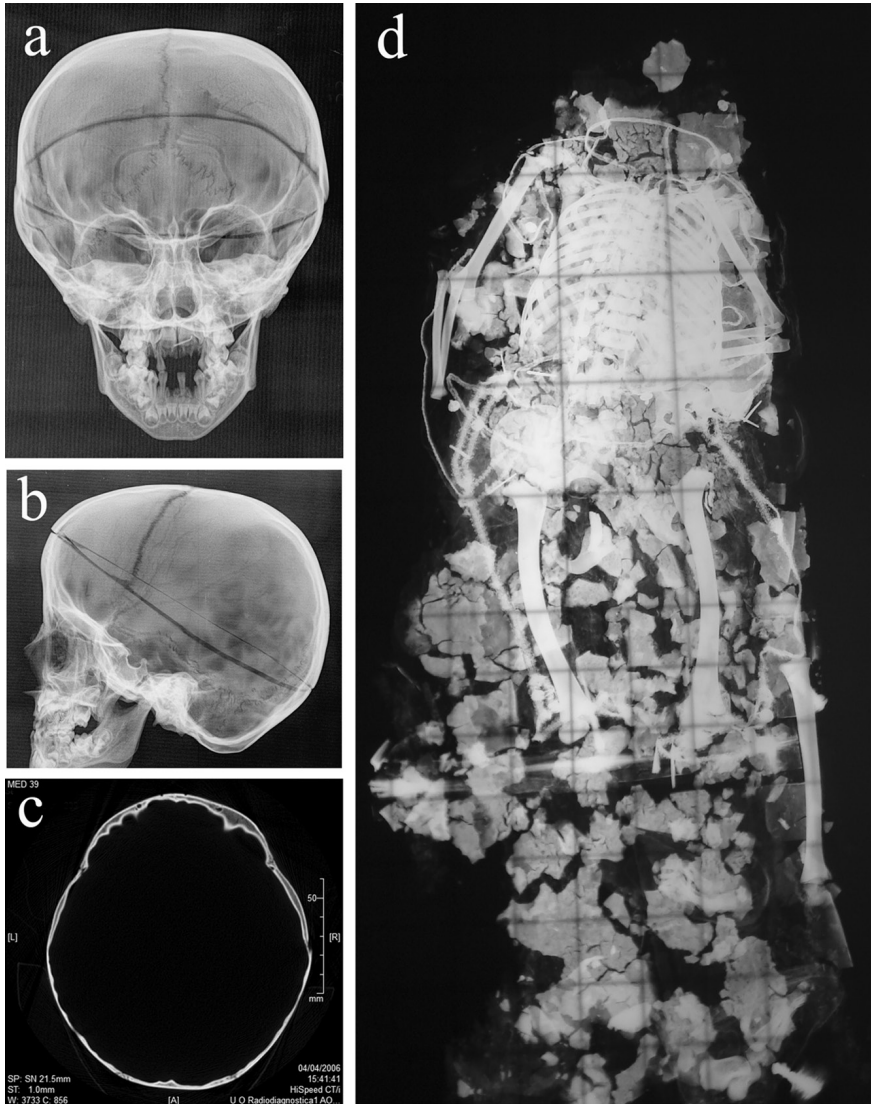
Radiological examination of Don Filippino: antero-posterior X-ray projection of the skull (a); latero-lateral X-ray projection of the skull (b); high vault CT of the skull (c); in situ radiographic examination of the skeleton (d)
